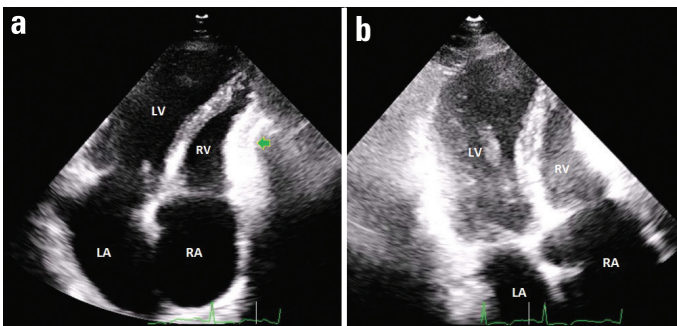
Two-dimensional transthoracic echocardiography showing severe thickening and calcification of the pericardium, leading to the strangulation of the heart. The calcification of the pericardium next to the basal and mid sections of the left ventricular free wall (a) and that next to the right ventricular free wall (b) are shown. Note that both the visceral and parietal pericardium are calcified
